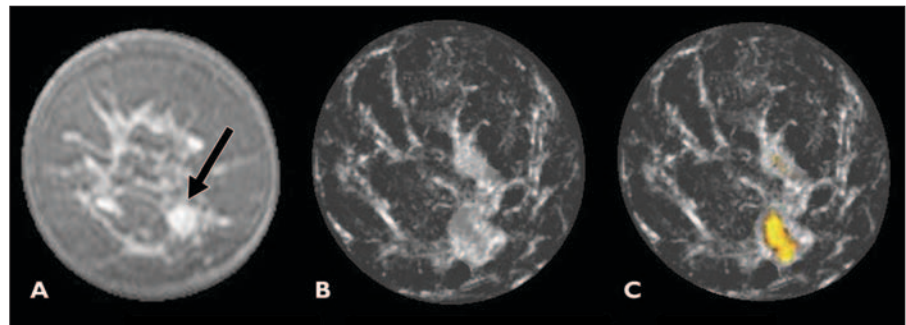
43-year-old woman with 1-cm fibroadenoma in 5-o'clock position. A and B, Coronal fat-saturated gadolinium-enhanced MR image (A) and ultrasound tomography image obtained after step 2 of fusion process (B) caused fibroadenoma (arrow, A) to be obscured by adjacent fibroglandular tissue because that entire region surpassed sound-speed threshold of 1.46 km/s. C and D, Final fused ultrasound tomography image now shows benign yellow overlay color from NOT operator function, whereby sound-speed threshold of 1.52 km/s was surpassed but attenuation threshold was not surpassed.
